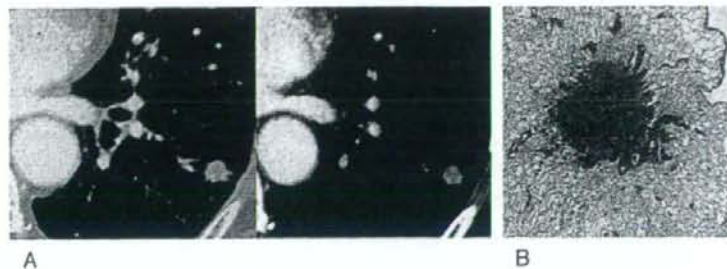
A recurrent case with a maximum SLP diameter of 4 mm. Solid adenocarcinoma with mucin: TS-CT (A); pathological preparation (B).
